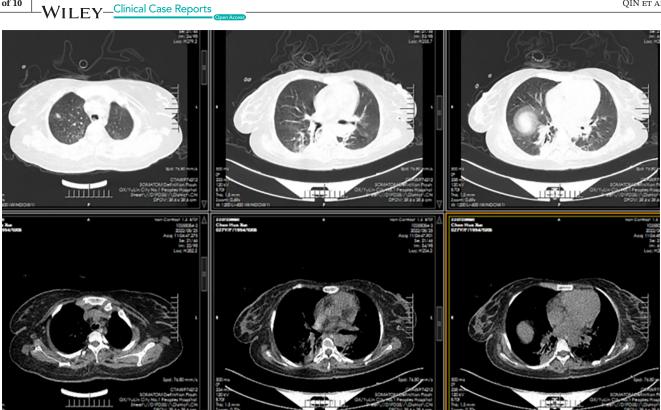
CT scan of the lungs 26 days post ECMO removal. On August 25th, the inflammatory lesions in both lungs were substantially resolved.
